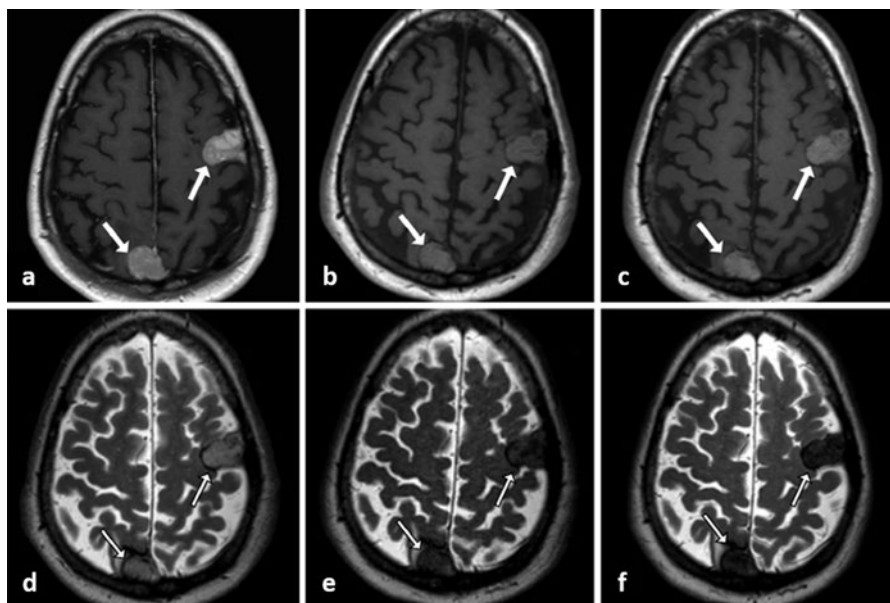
ProHance®-enhanced T1-weighted MR images in a patient with multiple pancreatic carcinoid tumor dural metastases reveal two masses (a, white arrows) that dissipate in 24 h for meningioma. On the other hand, the same masses exhibit mild enhancement (arrows) in T1-weighted images immediately after Feraheme® injection (b) that increases to 24 h (c). Axial T2-weighted MR images show a heterogeneous mild hyperintensity in the dural-based masses (arrows) on pre-contrast MRI (d) with new hypointensity in both masses (white arrows) immediately post ferumoxytol injection (e) that progressively darkens at 24 h (f). (Adapted with permission from [35])
